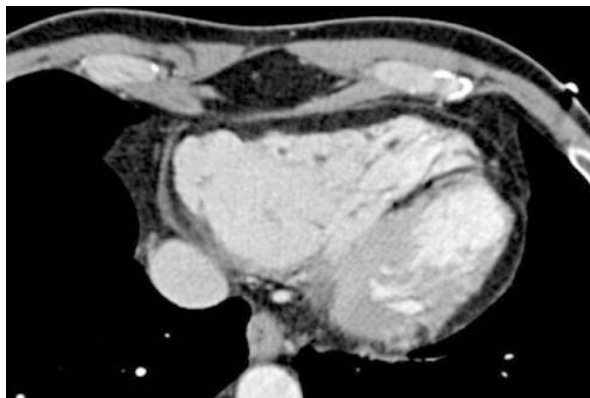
Arrhythmogenic RV dysplasia on cardiac CT. Reprinted with permission from “Value of Cardiac CT in Patients with Heart Failure” by Deepa Mangalat et al., *J Curr Cardiovasc Imaging Rep.* 2009 Dec; 2(6): 410–417. Springer Science and Business Media, LLC 2009
